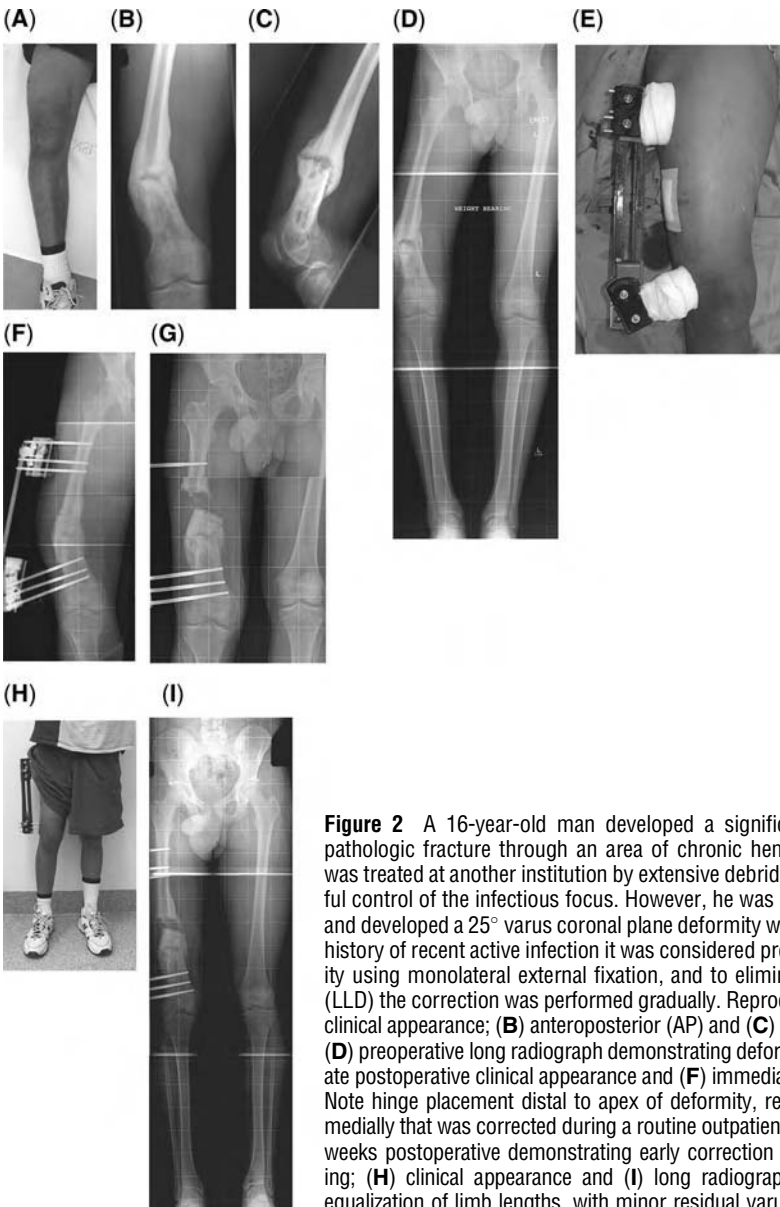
A 16-year-old man developed a significant femoral deformity after a pathologic fracture through an area of chronic hematogenous osteomyelitis. This was treated at another institution by extensive debridement, and resulted in successful control of the infectious focus. However, he was managed in traction and a cast, and developed a 25° varus coronal plane deformity with 3.5 cm shortening. Given the history of recent active infection it was considered preferable to address this deformity using monolateral external fixation, and to eliminate the leg length discrepancy (LLD) the correction was performed gradually. Reproduced here are: (A) preoperative clinical appearance; (B) anteroposterior (AP) and (C) lateral preoperative radiographs; (D) preoperative long radiograph demonstrating deformity including LLD; (E) immediate postoperative clinical appearance and (F) immediate postoperative AP radiograph. Note hinge placement distal to apex of deformity, resulting in secondary translation medially that was corrected during a routine outpatient visit; (G) AP radiograph at four weeks postoperative demonstrating early correction and medial translation developing; (H) clinical appearance and (I) long radiograph at 10 weeks, demonstrating equalization of limb lengths, with minor residual varus of less than 2°.
